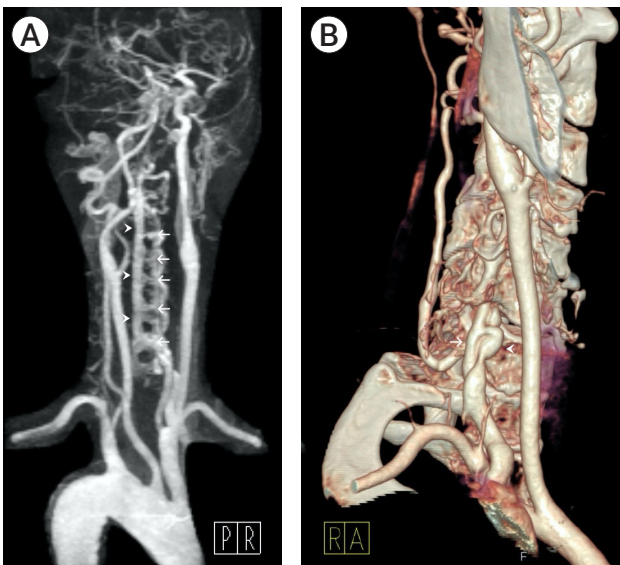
(A) Maximum intensity projection reconstruction of neck carotid magnetic resonance angiography shows dilated intervertebral veins (arrows) and anterior internal vertebral venous plexus (arrowheads) in the cervical spine from C1 to C6. (B) Volume-rendered images of neck carotid computed tomographic angiography reveal a fistulous connection between the extraosseous right vertebral artery (arrow) and its adjacent vertebral vein (arrowhead) just before entry into C6 transverse foramen.
